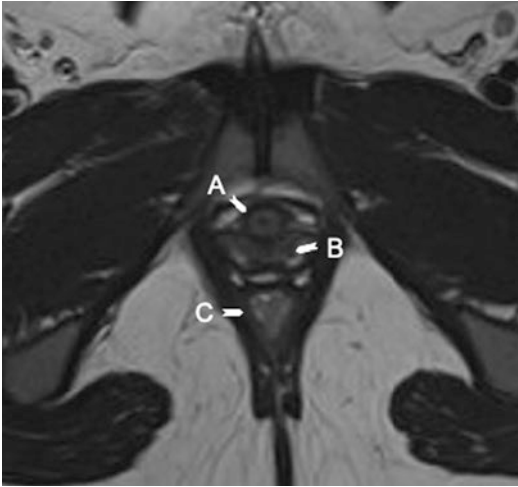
Female perineum. Axial T2 MRI views of the female perineum. The urethra (A) can be seen anterior to and in close proximity with the anterior wall of the vagina (B). Posterior to the vagina is the rectum (C)
